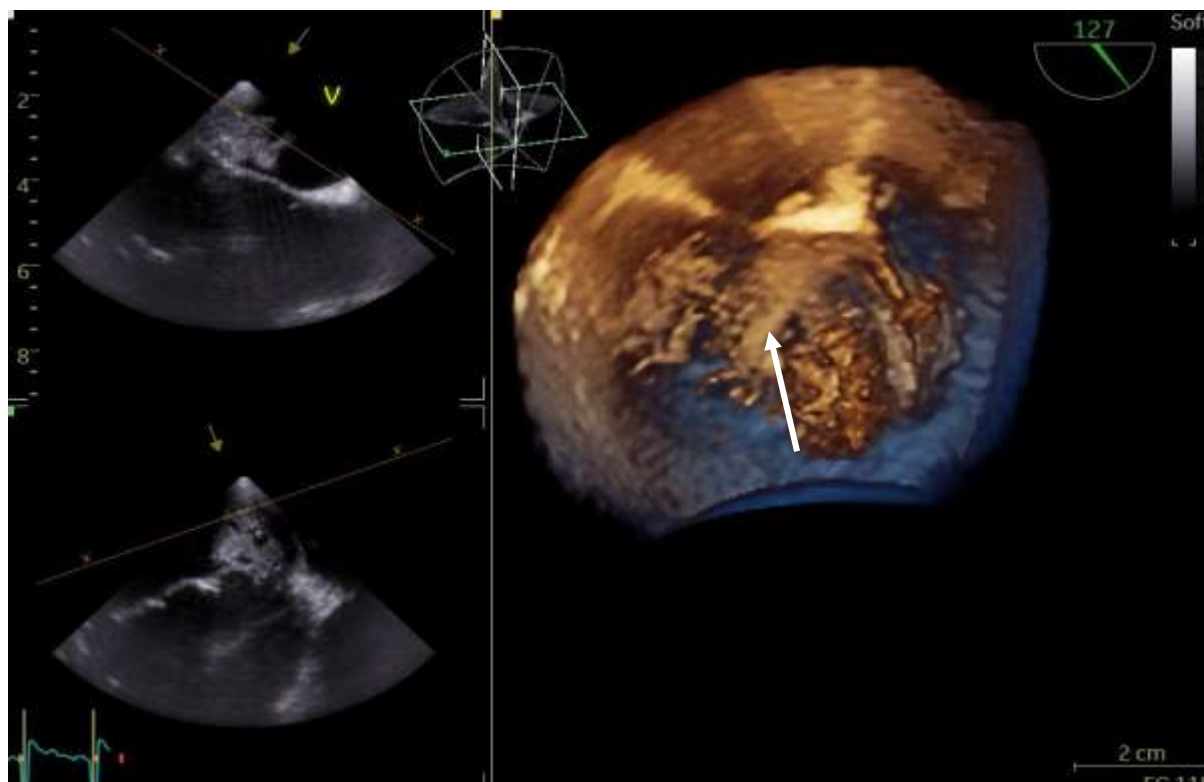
A 3-dimensional transthoracic echocardiogram section at 120 degrees, with the view of the vegetation.
